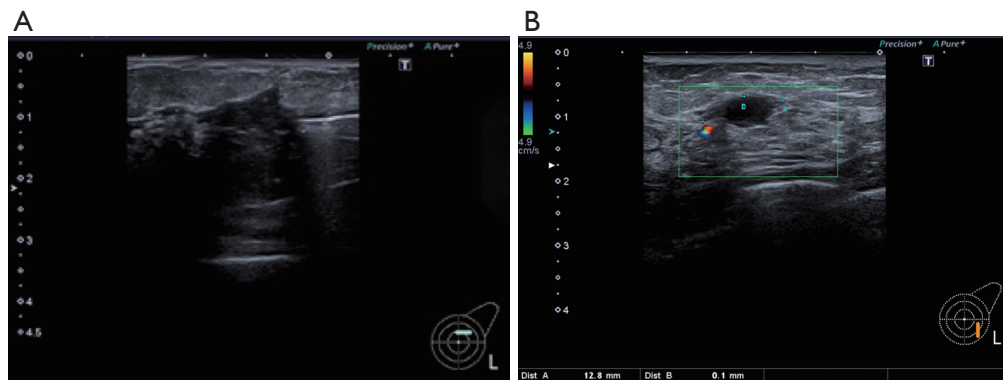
Ultrasound appearance of idiopathic granulomatous mastitis. (A) An area of mixed echogenic change measuring in excess of 40 mm with both solid and fluid components. (B) Hypoechoic area in the skin layer with fistula tracking down to an irregular hypoechoic area with increased vascularity deep within the breast tissue. Surrounding chronic inflammatory changes.
